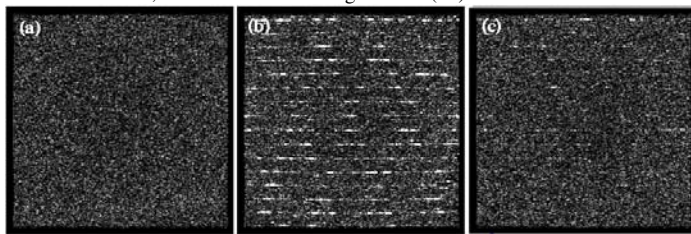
MR image noise induced by US (a) Baseline, (b) During US capturing with US system shielded and probe window unshielded, and (c) During US capturing with shielded US system and probe window
